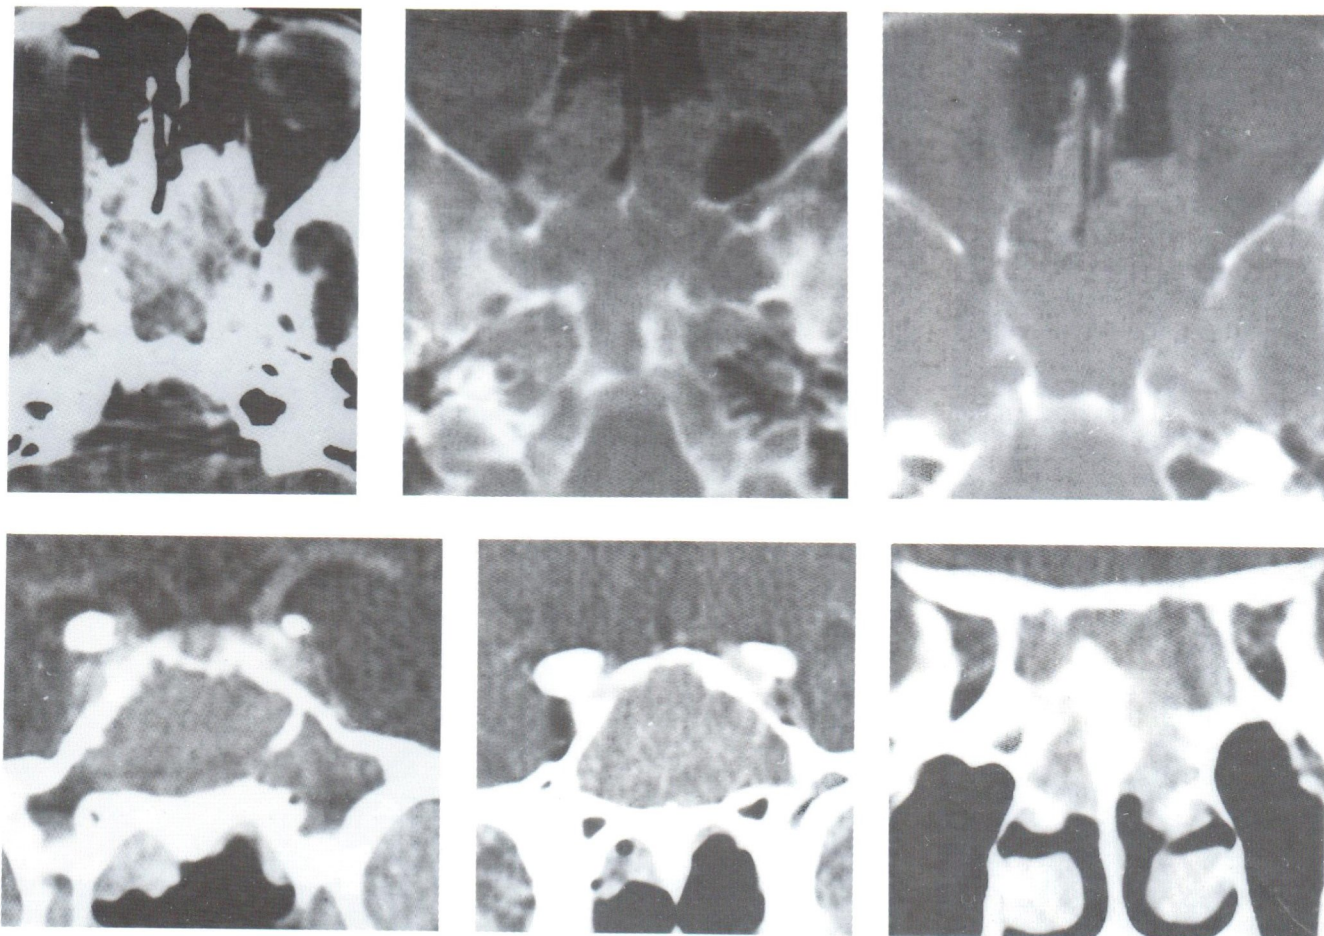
Case 1. Axial and coronal views enhanced CT scan of the paranasal sinuses showed soft tissue lesion of rather homogeneous density in the expanded sphenoid sinus and posterior compartment of both ethmoid sinuses. The intersphenoid sinus septum disappeared. The cavernous sinuses and the pituitary gland were normal.
